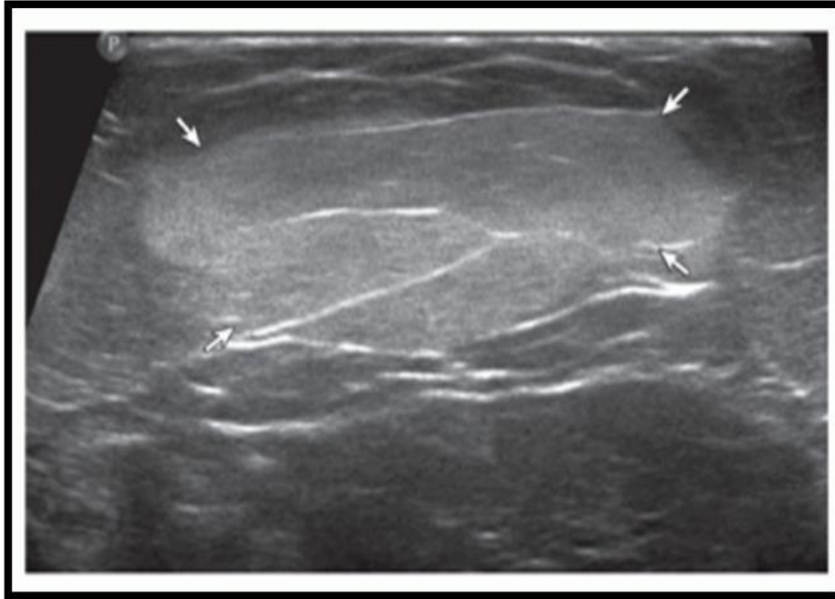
Lipoma. Ultrasound image shows oval hyperechoic subcutaneous lipoma (arrows) with internal linear hyperechoic fibrous tissue (pathologically proven) [10].
